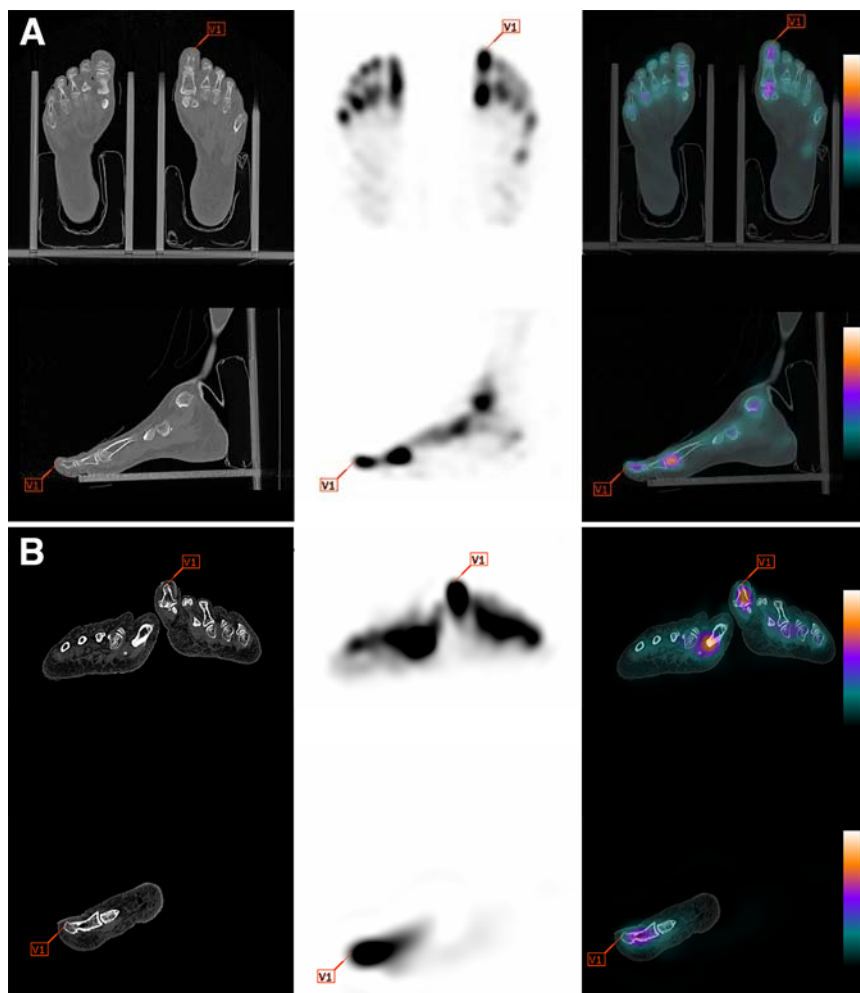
Example of anatomic landmark of the left distal phalanx of the great toe in patients with (A) and without the support (B). From left to right: CT, SPECT and SPECT/CT fusion images.
